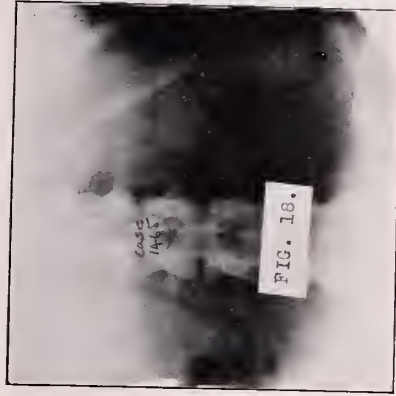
Normal radiographic outline of kidney. Figs. 19 and 19a.—Small kidney stone, shown to be in lower pole of kidney, by injecting pelvis, for orientation.
